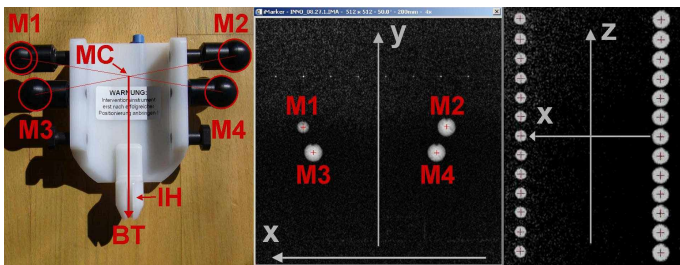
Left: Application module. IH: Instrument holder, BT: Biopsy trajectory, M1-M4, MC: Markers and Centroid. Center: Transverse MR image. Right: Overlay of coronal images in 13 AMO z -positions.
